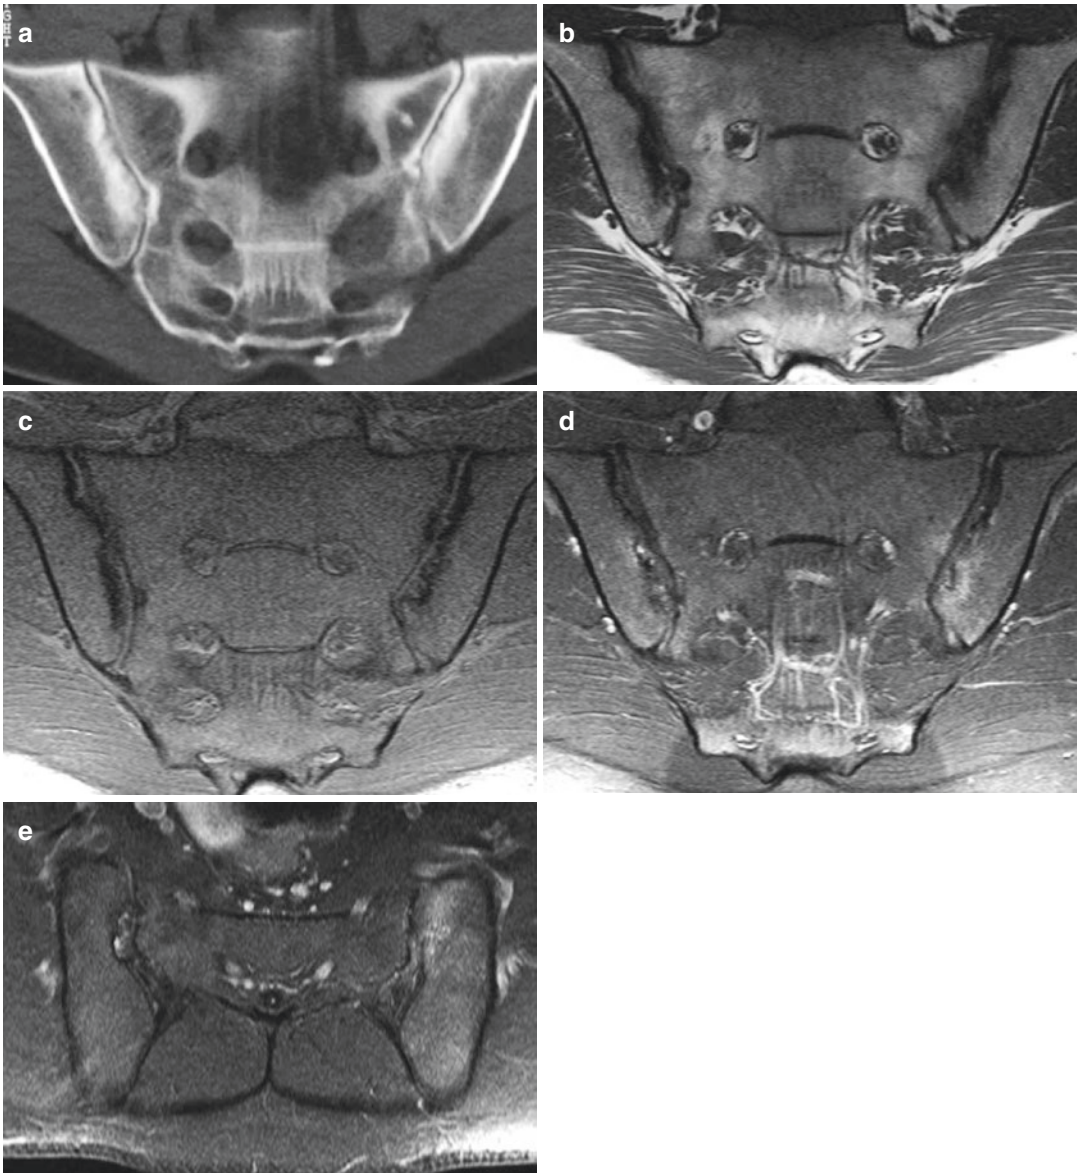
Sacroiliitis with both active and chronic changes. (a) Semi-coronal CT slice showing bilateral joint space narrowing and erosion with subchondral sclerosis. MRI, (b) coronal T1, (c) T1 FS and (d) T1 FS post-contrast and (e) semi-axial T1 FS post-contrast. The
